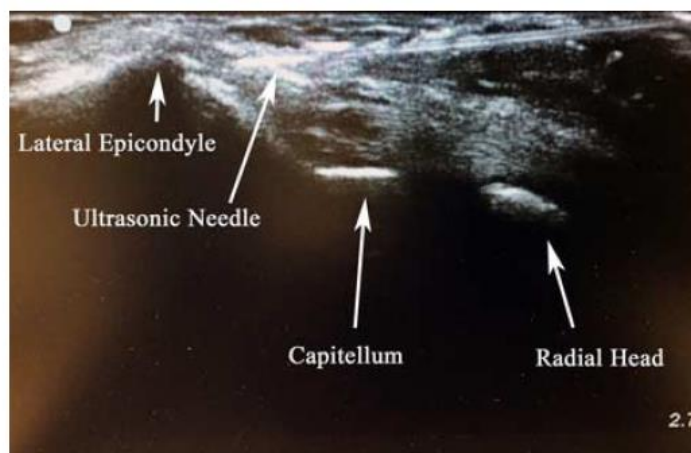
Ultrasonic image of the TX1 probe directed toward the lateral epicondyle, a common site for tendinosis and interstitial tears. full color online
